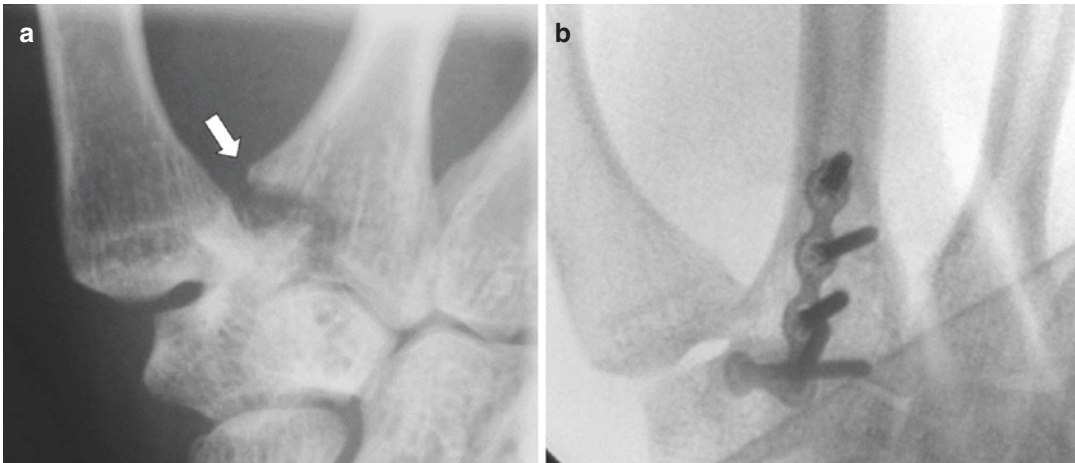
(a) An AP X-ray view of fracture of base of the second metacarpal, and (b) postoperative X-ray showing internal fixation. With permission from Carlos Henrique Fernandes
